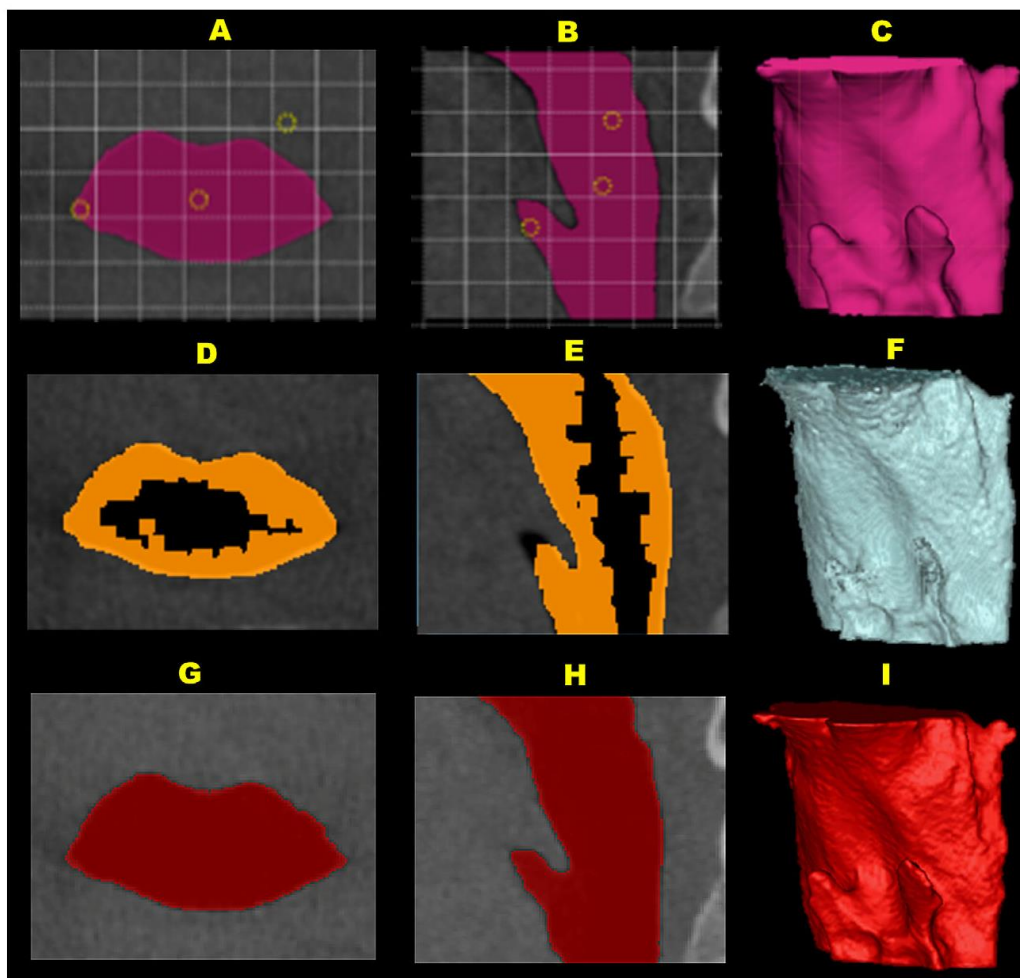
Examples of the oropharynx segmentation process with 3 imaging software programs: A, D, and G, axial views and B, E, and H, sagittal views of the oropharynx segmentation processes in the CBCT images; C, F, and I, 3D models of a patient's oropharynx obtained from segmentations. A-C, Segmentation process with Dolphin3D (*pink*) was based on addition and growth of seeds (*yellow circles*) that spread, matched, and filled the oropharynx airway. D-F, Segmentation with Ondemand3D (*orange*) showing, in the axial and sagittal views, empty spaces (*black*) without segmentation in some areas and overflowed in other regions. G-I, Segmentation with ITK-Snap (*red*). The segmentation matched precisely the oropharynx in the axial and sagittal views.
